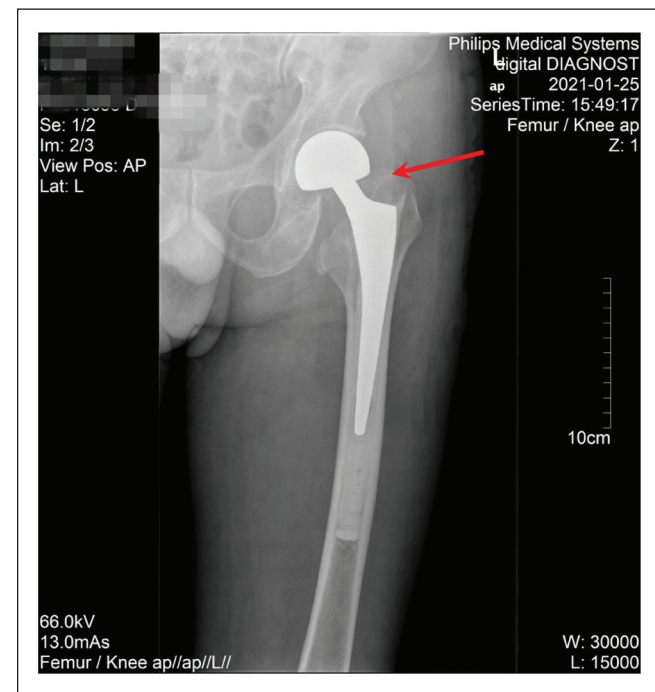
Hip X-ray on 25 January 2021, showing that the left femoral head replacement surgery was successful, with the cemented prosthesis in good position (red arrow).
